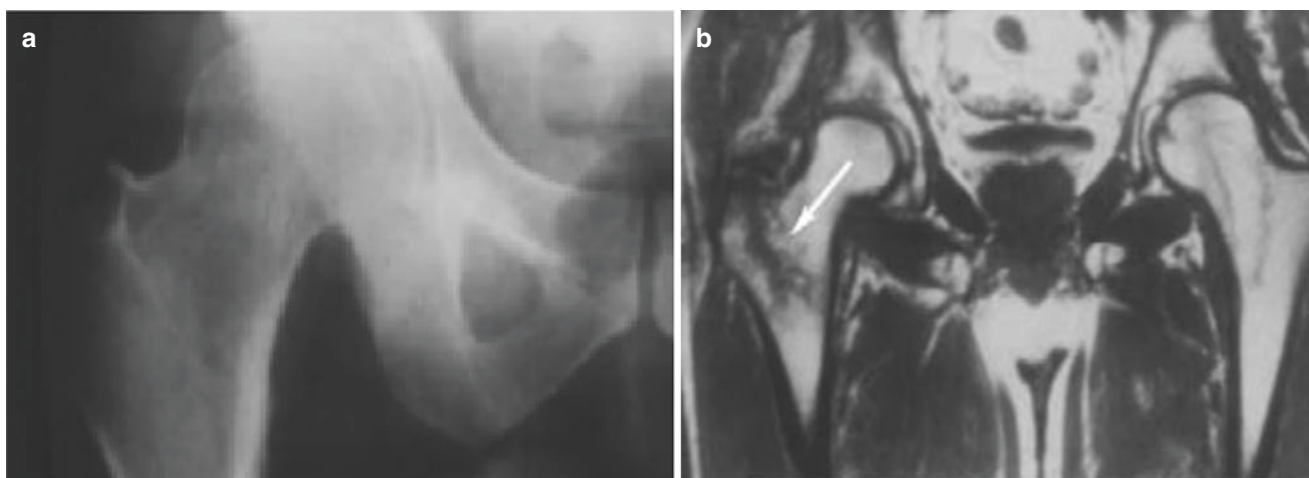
(a) AP X-ray of R hip. (b) Coronal slice pelvic MRI. The MRI shows an occult right intertrochanteric femur fracture not visualized on plain films [144] (Fig. 81 a & b in. Manninger, J, and K Fekete.
